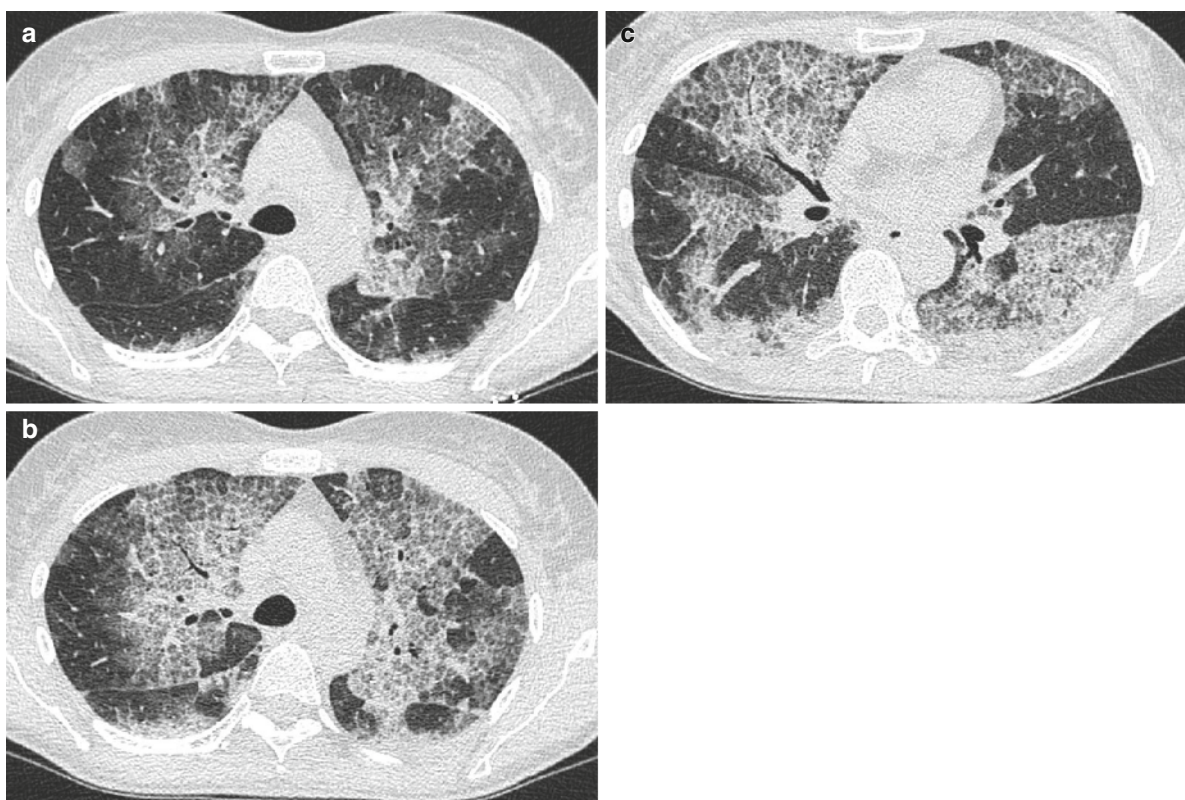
(a–c) High-resolution computed tomography (HRCT) in a 59-year-old woman with progressive primitive alveolar proteinosis despite therapeutic whole lung lavage. Initial HRCT (a) typically shows diffuse ground-glass attenuation with superimposed
